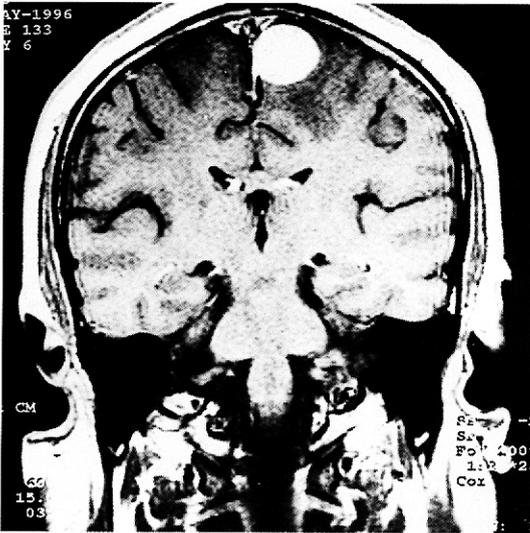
A magnetic resonance image showing a well demarcated peripheral enhancing mass over the left superior parasagittal sinus.
